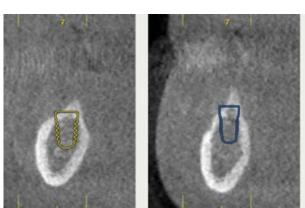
Planification of dental implants in the cone-beam with the software BTI-Scan III
